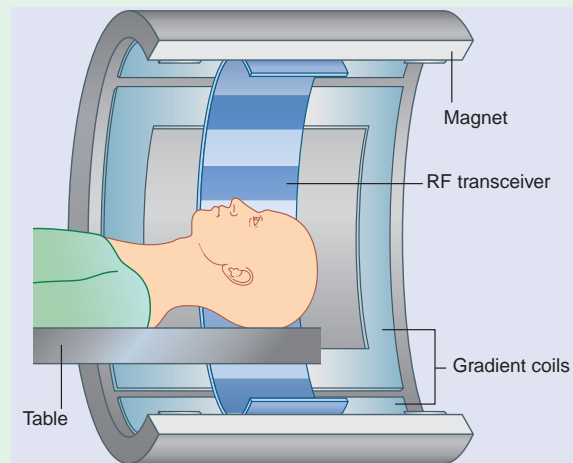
The MRI machine. Outermost is the magnet. Innermost is the radio-frequency transceiver. In between are the gradient coils.
